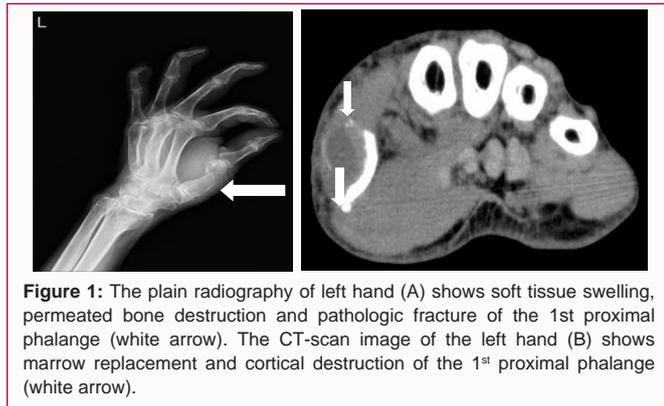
The plain radiography of left hand (A) shows soft tissue swelling, permeated bone destruction and pathologic fracture of the 1st proximal phalanx (white arrow). The CT-scan image of the left hand (B) shows marrow replacement and cortical destruction of the 1st proximal phalanx (white arrow).
